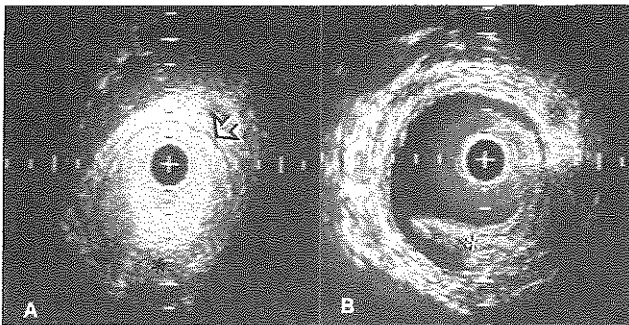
(A) Intravascular ultrasound images obtained from a 66-year-old man with lower limb ischemia. Before intervention, blood was seen to be extremely echogenic indicating a flow rate of < 0.1 L/minute. The black band corresponds to the muscular media (open arrow). A lesion was evident (*). (B) Following dilatation, the lesion was dissected from the arterial wall at its thinnest portion. The lesion area did not change (14 mm^2), whereas the free luminal area changed drastically from 27 to 38 mm^2 . Calibration 1 mm .
